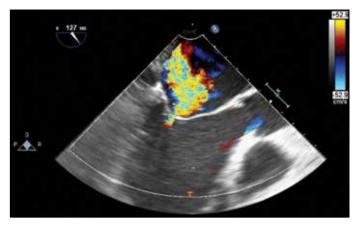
Transesophageal echocardiography reveals severe mitral regurgitation from the middle segments of both leaflets (A2 and P2 segments) in the left ventricular outflow tract view
